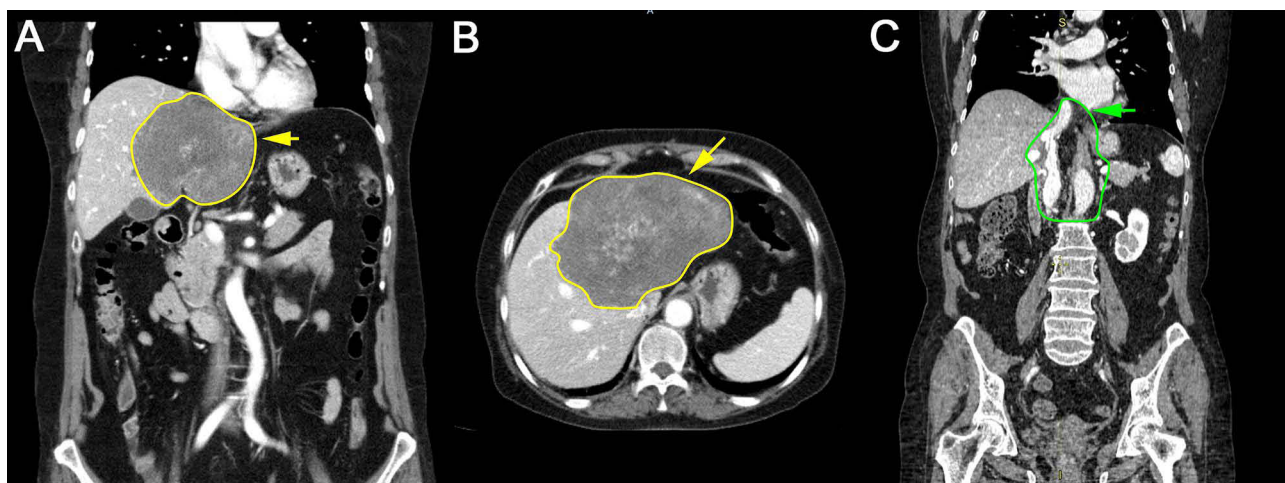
Computed tomography of the abdominal organs and retroperitoneal space with contrasting. (A and B) The image of cyst of the left lobe of the liver (of parasitic origin), dimensions are 19×15 cm with uneven clear contours. (A) Frontal plane, (B) Axial plane, yellow contours and arrows indicate the cyst margins. (C) The image in dynamics three months after the surgery, frontal plane, no relapse as shown by bright green contour and arrow.
